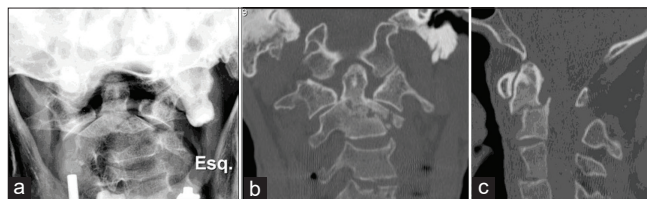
(a) Admission X-ray (transoral view) and computed tomography (CT) scan. (b) June 2016: Anderson and D'Alonzo Type III odontoid fracture with the left lateral mass extension (CT scan, coronal view) (c) June 2016: Anderson and D'Alonzo Type III odontoid fracture with the left lateral mass extension (CT scan, sagittal view).
